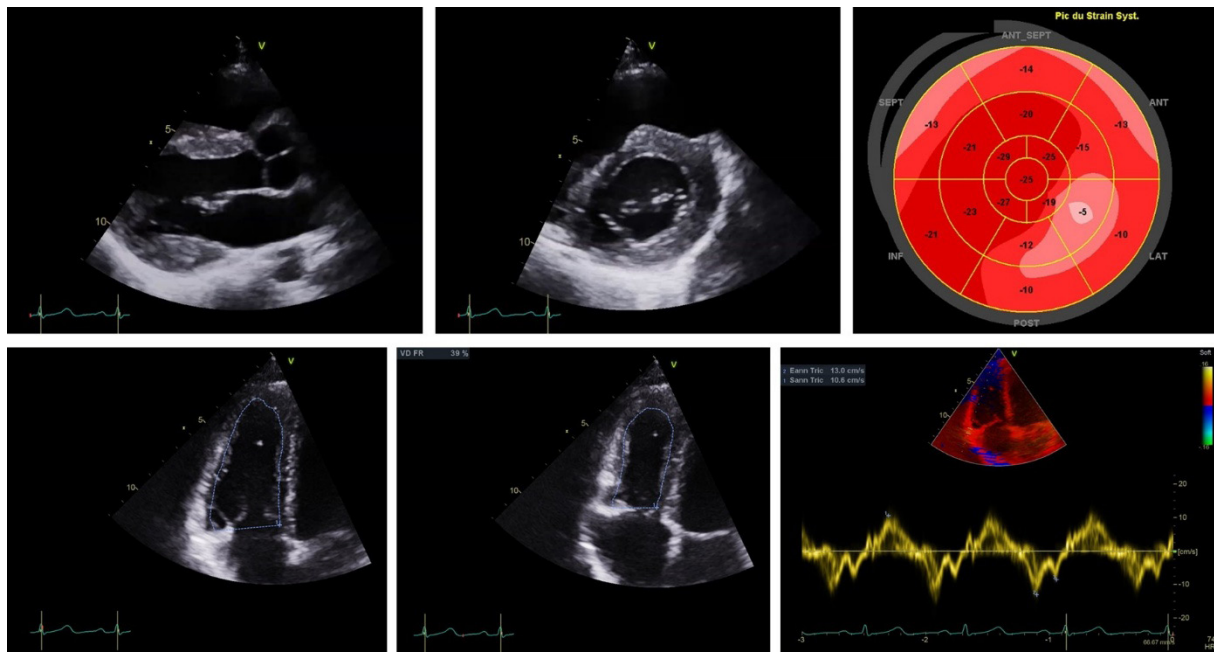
Transthoracic echocardiography: (a) Parasternal long axis view and (b) parasternal short axis view showing localised hypertrophy in the basal IVS segment. (c) Global longitudinal strain—showing mild longitudinal dysfunction (-17.9% with a patchy distribution of abnormal areas). (d) RV-centred apical four chambers view showing diastolic RV area and (e) systolic RV area, with an RV fractional area change of 39% . (f) Tissue Doppler tricuspid S wave velocity of 10.5 cm/s showing a normal right ventricle longitudinal function.
